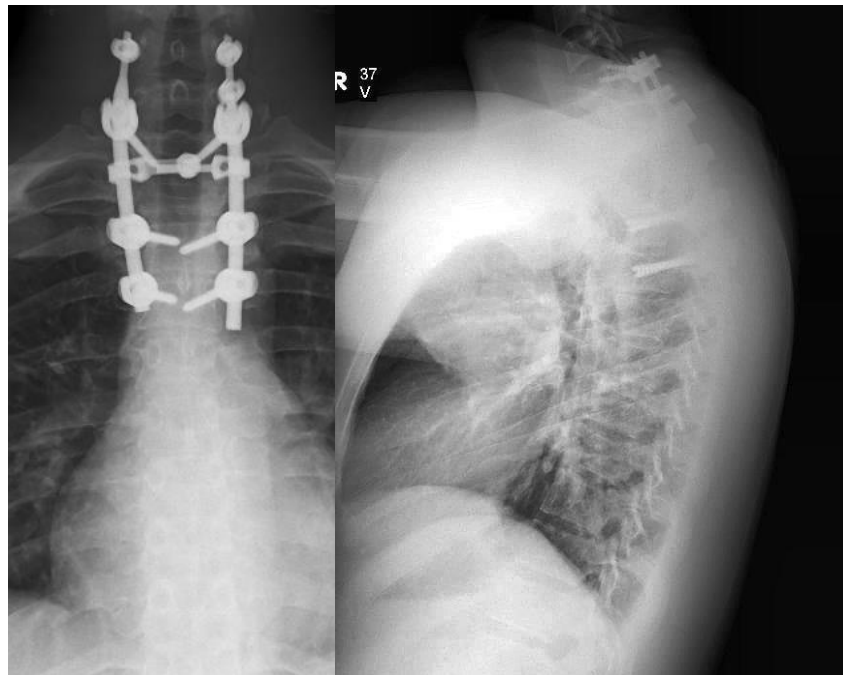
Control X-Ray on 3rd month after surgery
